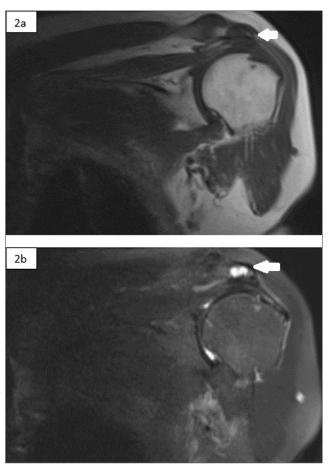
2a-Coronal T1 MRI images showed that well-circumscribed hypointense content in acromion, 2b-The lesion well-circumscribed hyperintense content which has some focal regions of signal drop out where calcification was present and subacromial effusion on fat suppressed T2-weighted images
